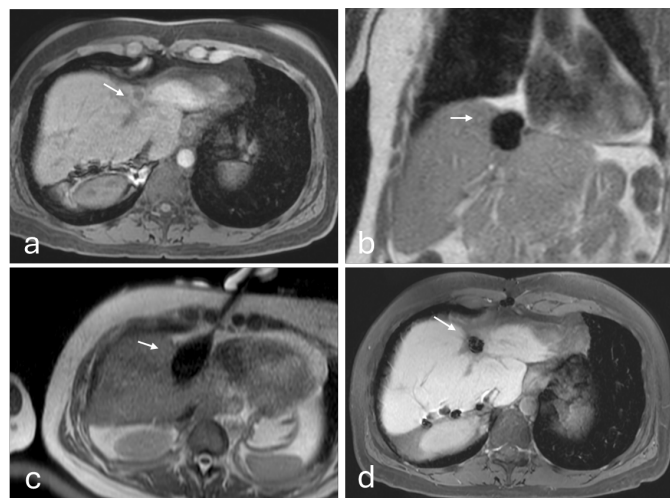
57-year-old female with colorectal cancer metastasis at the anterior hepatic dome, 3.2 mm from the pericardium - the closest cardiac proximity in this series. (a) Pre-procedural axial contrast-enhanced T1-weighted MRI demonstrating the 10-mm enhancing lesion at the anterior dome. (b) Coronal T2-weighted MRI confirming the 3.2 mm lesion-to-pericardium distance. (c) Intraprocedural axial T2-weighted MRI during active cryoablation demonstrating cryoneedle placement (arrow) and iceball formation at the dome; preserved T2 signal between the iceball periphery and the pericardial reflection confirms absence of myocardial contact at the closest proximity in this series. (d) Follow-up axial T2-weighted MRI demonstrating a hypointense ablation scar without local tumor progression.
